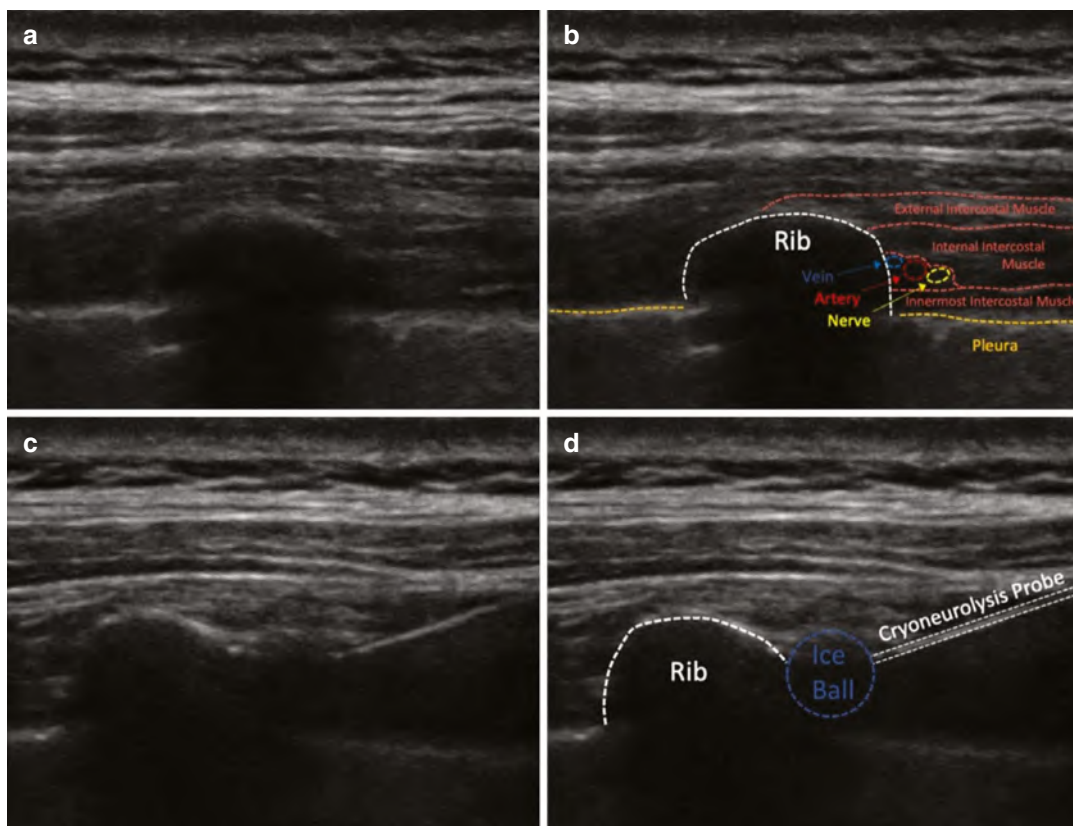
Ultrasound images of percutaneous cryoneurolysis of an intercostal nerve. (Used with permission from John J. Finneran IV, MD, who retains the rights to the image)
